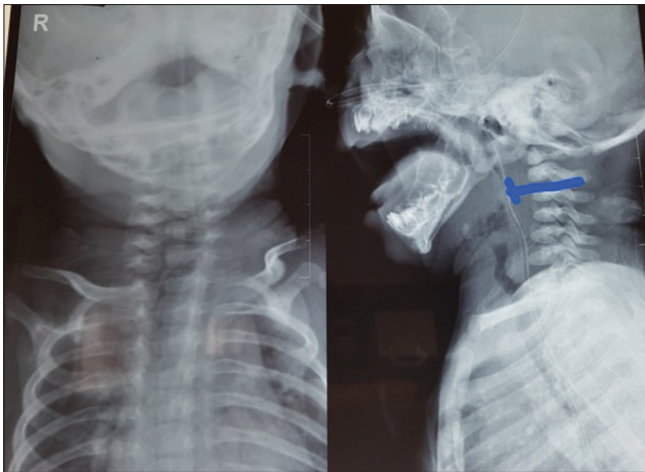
X-ray of neck AP and lateral view showing obscuring of air shadow
